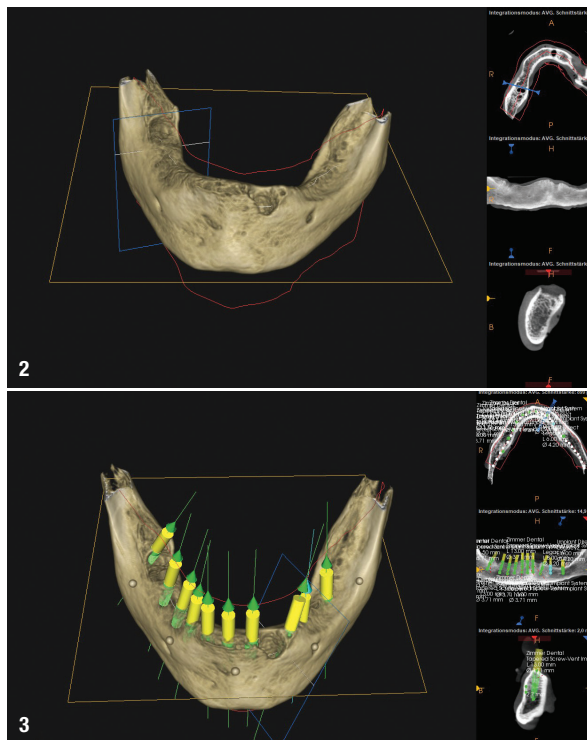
CBCT scan of the body of the mandible in the planning program, showing broad portions of cortical bone and dense cancellous structures.
